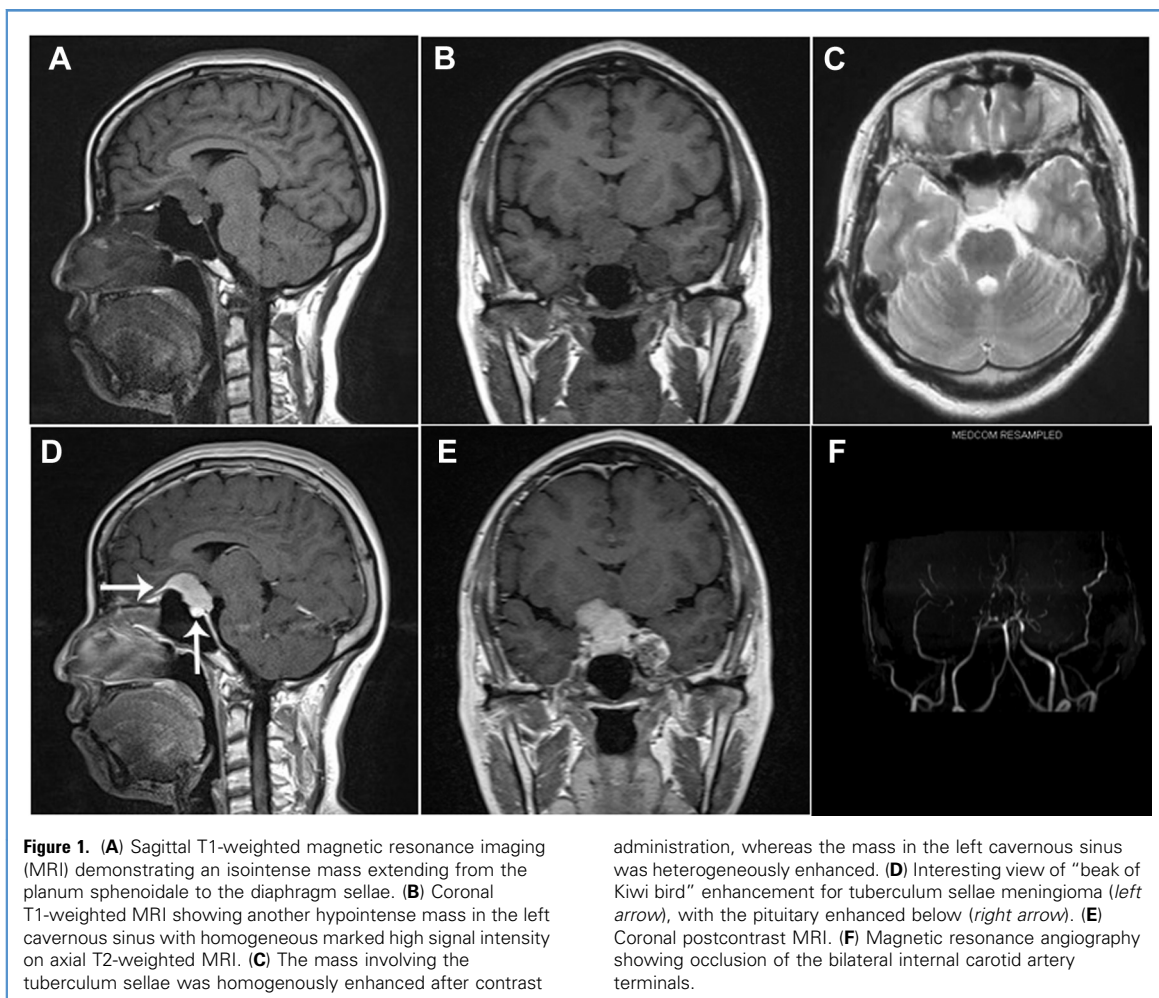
(A) Sagittal T1-weighted magnetic resonance imaging (MRI) demonstrating an isointense mass extending from the planum sphenoidale to the diaphragm sellae. (B) Coronal T1-weighted MRI showing another hypointense mass in the left cavernous sinus with homogeneous marked high signal intensity on axial T2-weighted MRI. (C) The mass involving the tuberculum sellae was homogeneously enhanced after contrast
